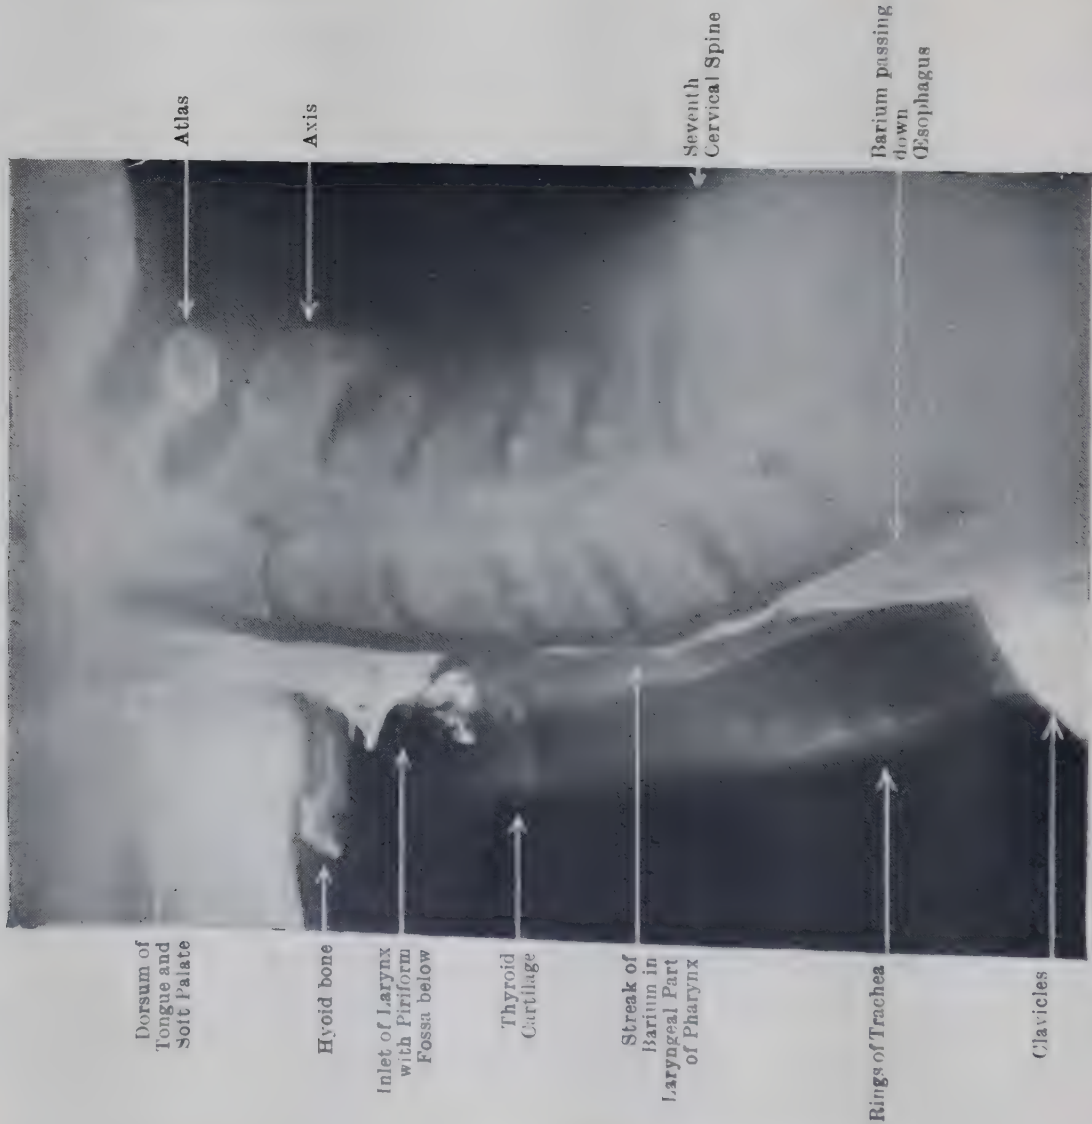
LATERAL RADIOGRAPH AS THE BARIUM PASSES INTO THE ESOPHAGUS.
